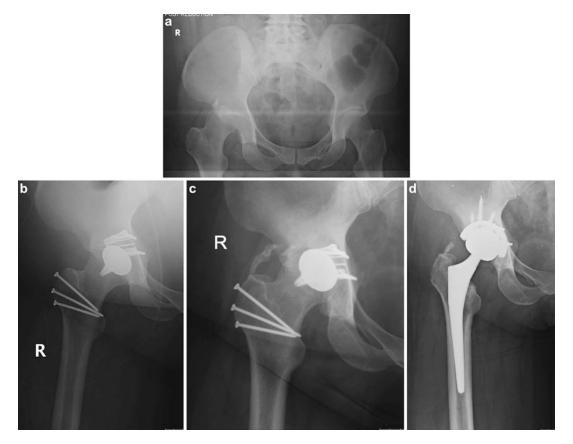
Vignette 2: Complex total hip replacement. (a) Injury AP radiograph showing a dislocated right hip with acetabular fracture (b) Postoperative AP radiograph showing acetabular fixation and partial hip resurfacing (c) AP
